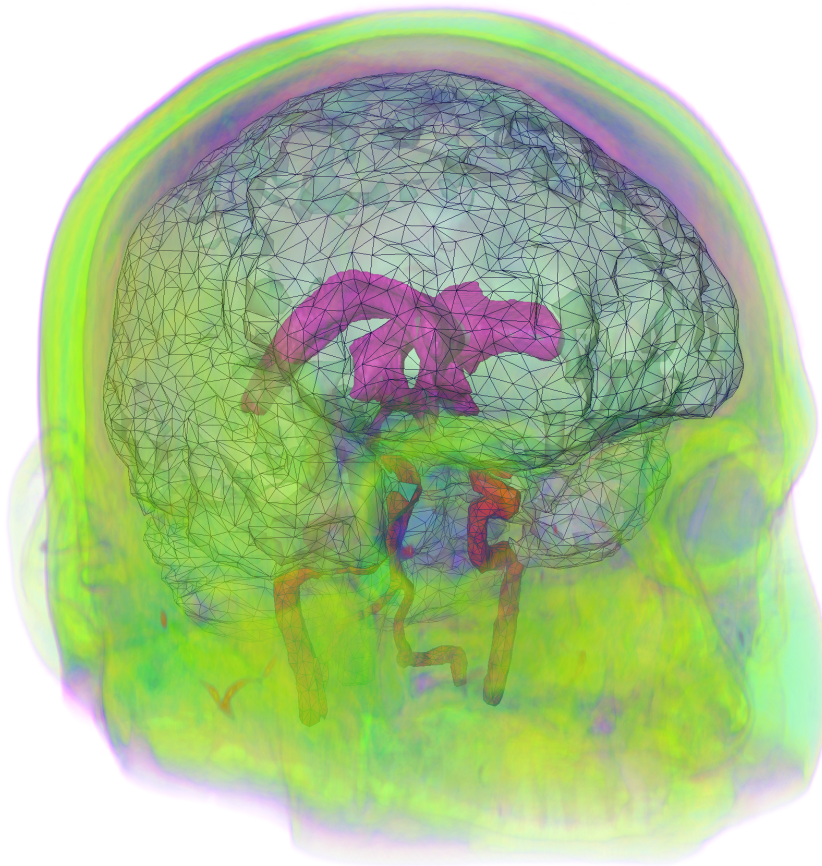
Segmented brain geometry garnered from patient-specific MR imaging. The lime green area shows features such as the skull, skin and bone; the parenchyma is meshed with large triangles with an emerald green shading; the cerebral ventricles (where CSF is produced) are shaded in magenta; and the important cerebral blood vessels are segmented and shaded in red.
